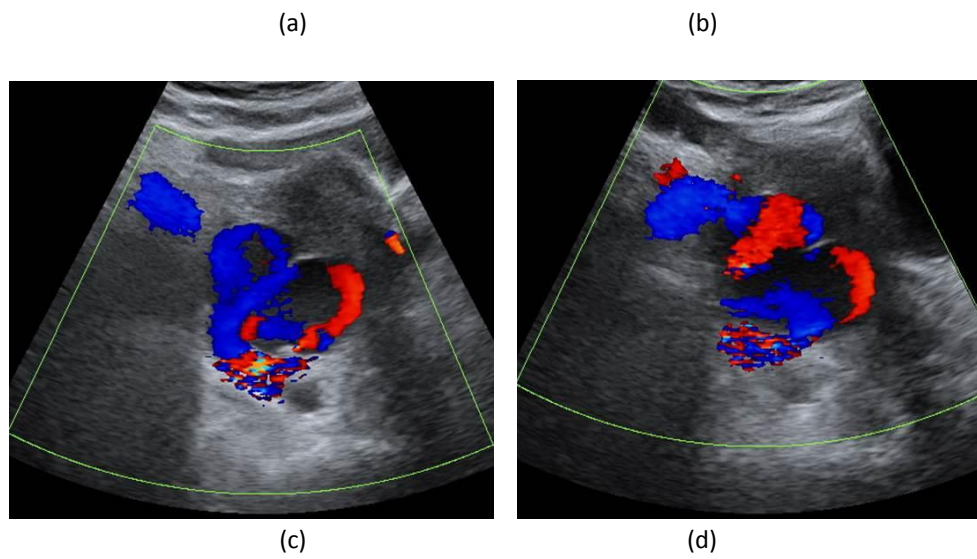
Color Doppler sonography demonstrate a mosaic pattern with intermixing of colours within the cystic lesion representing turbulent flow.
